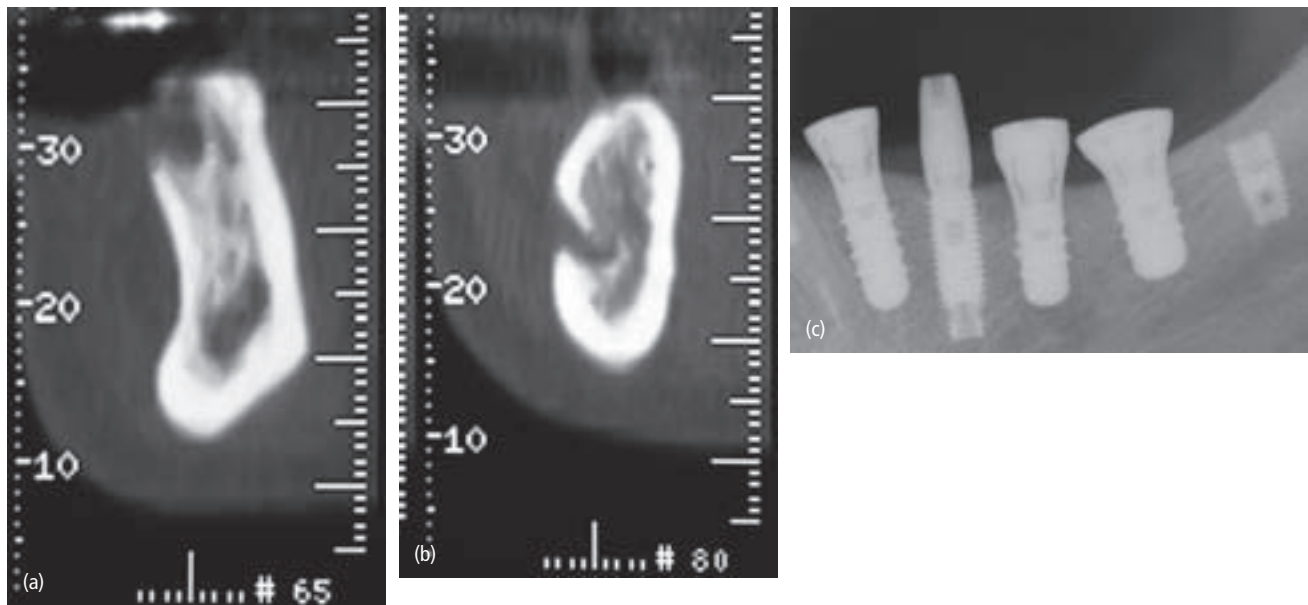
Soft-tissue pain after implant insertion. (a) CT scan demonstrating damage to the buccal plate of bone at site 21 requiring a guided bone regeneration procedure. (b) The mental foramen was located by tooth 19. (c) Implants inserted at sites 21, 19, and 18. Implants 20 and 17 were previously there. The implant at 20 was to be used and 17 was left submerged.
